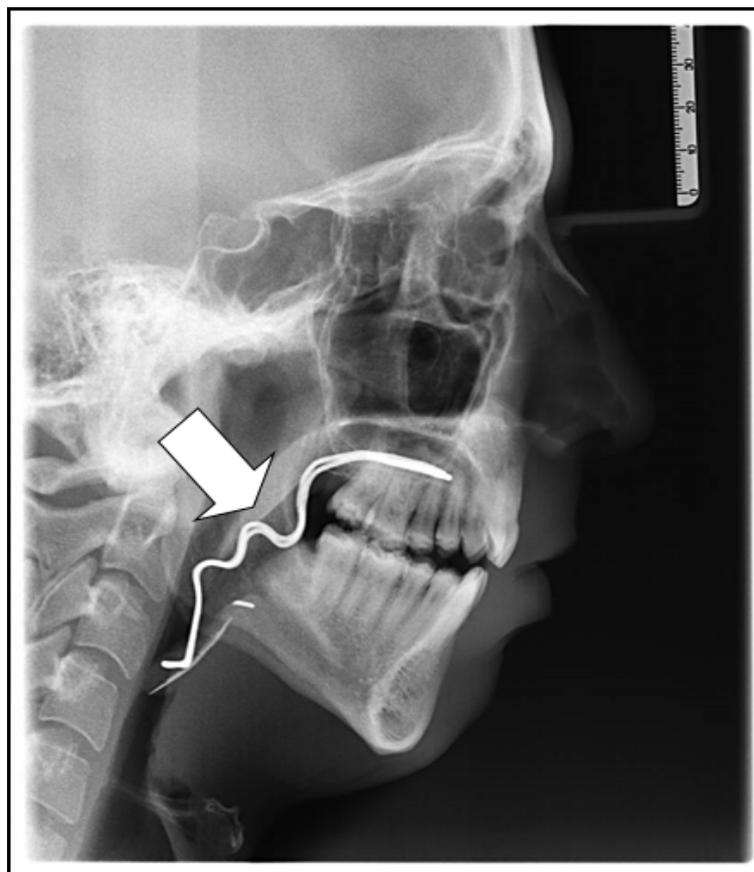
Cephalometric radiography. The sagittal plane shows Caram's lingual orthosis *in situ*. It can be observed a space between the soft palate and tongue position promoted by the oral appliance (white arrow) and an increase in the oropharynx caliber.
